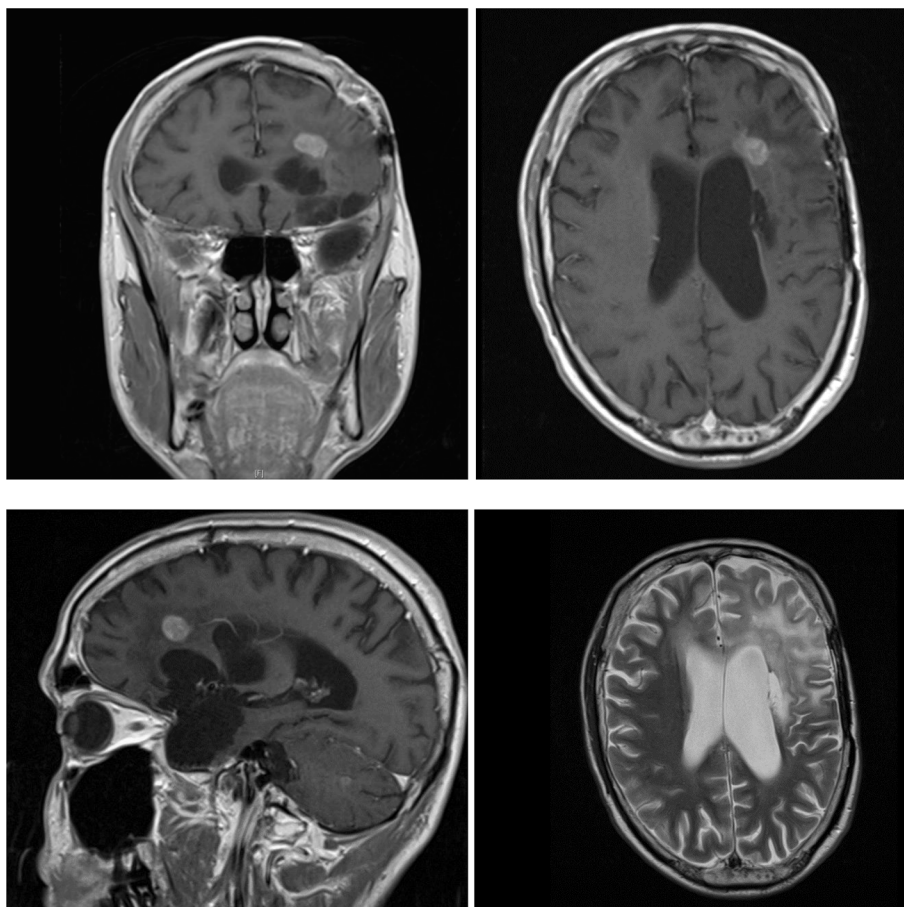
December 2018: MRI (T1 with contrast coronar, axial, sagittal and T2 axial), Status before radiation.
